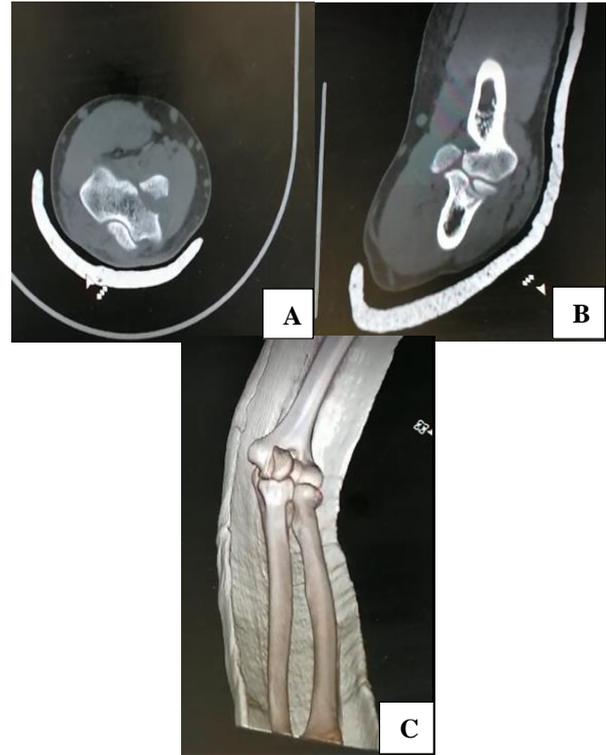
Computed tomography scan (A) axial view; (B) sagittal view; and (C) cut in 3D reconstruction.
